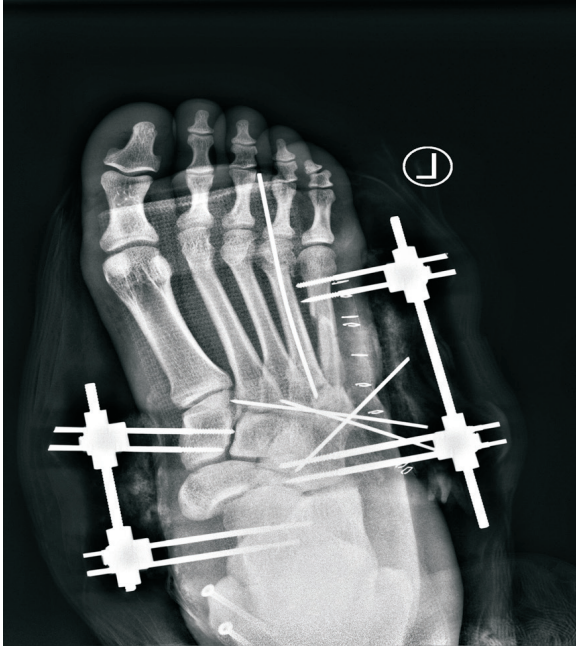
Immediate postoperative radiograph showing good anatomic alignment.
